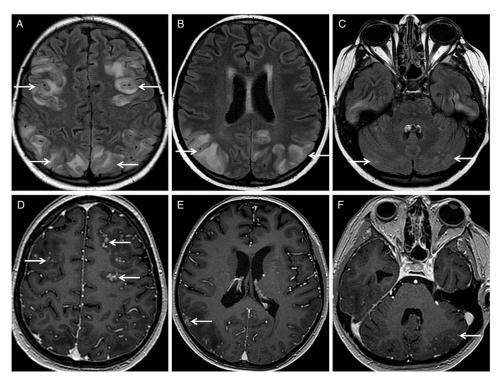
HLH in a 12-year-old with long-standing immune dysregulation (fever, cytopenia, splenomegaly). Axial FLAIR (A, B) images reveal bilateral, near-symmetric, gyriform FLAIR hyperintensity with cortical swelling with similar signal abnormality in the juxtacortical white matter in the frontal and parietal lobes (arrows in A, B). Axial FLAIR (C) reveals patchy hyperintensities in the cerebellar hemispheres as well (C). Contrast-enhanced axial 3D-T1 sequences (D-F) reveal multiple, punctate foci of cortical enhancement, most accentuated in the frontal lobes, more on the left (arrows in D), with few foci of enhancement in the right parietal lobe (arrow in E), and left cerebellum (arrow in F).
